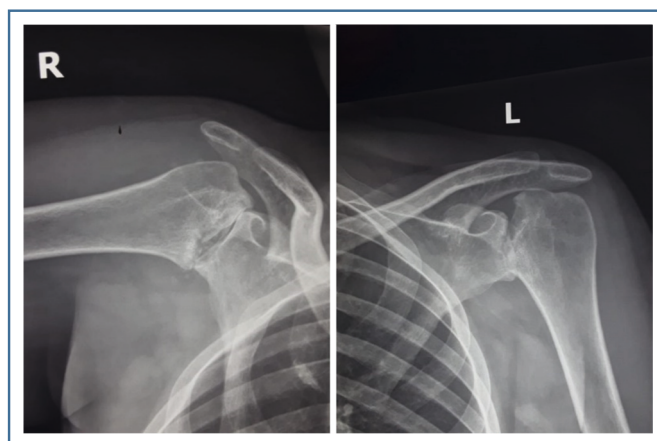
Antero-posterior plain radiographs showing complete erosion and collapse of the humeral heads bilaterally, with spared glenoids (Cruess Grade IV) (eight months after initial presentation).
